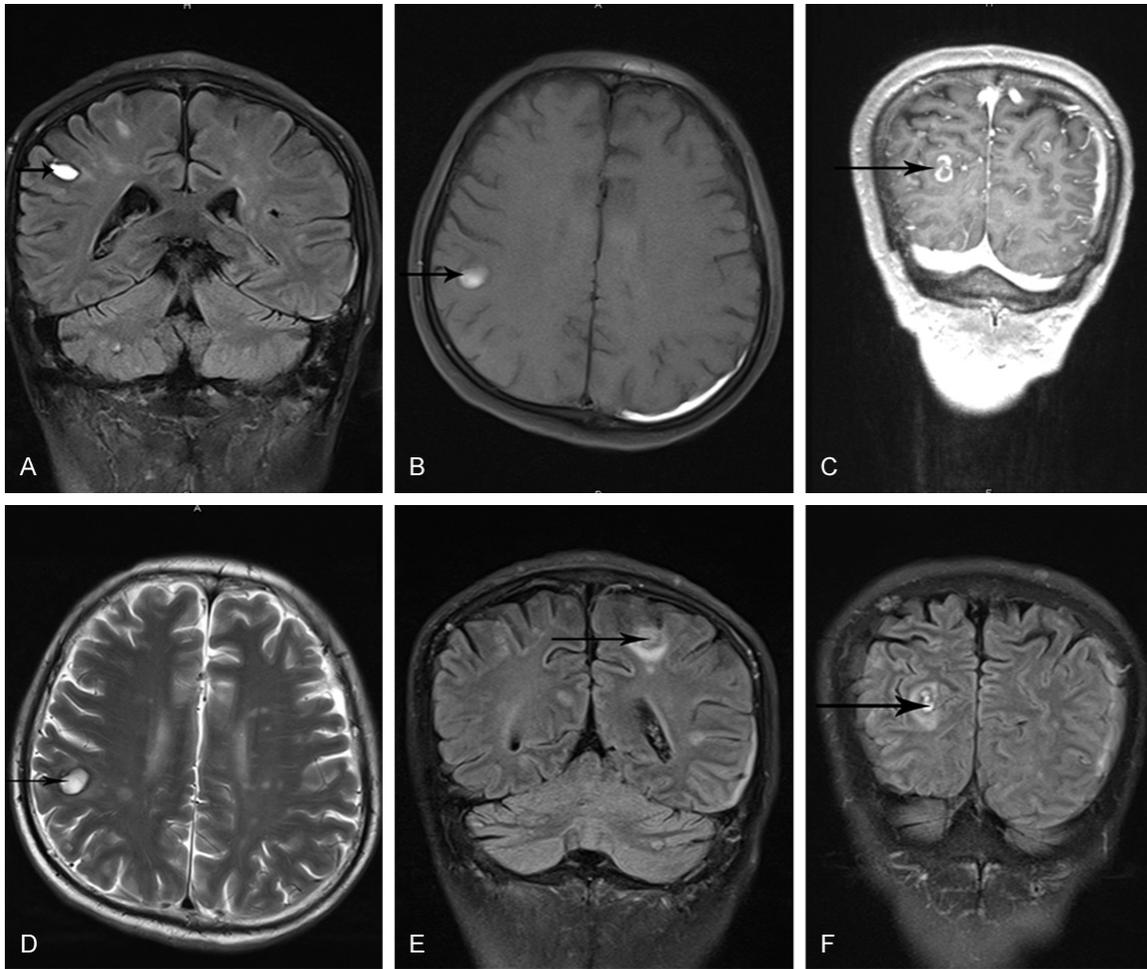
Intracranial MRI scan with enhancement, February 5, 2015. A-F. Show ring enhancement of the right frontal lobe. The left pituitary gland is ca 4 × 2 mm, with relatively low contrast enhancement; a pituitary adenoma was considered.
